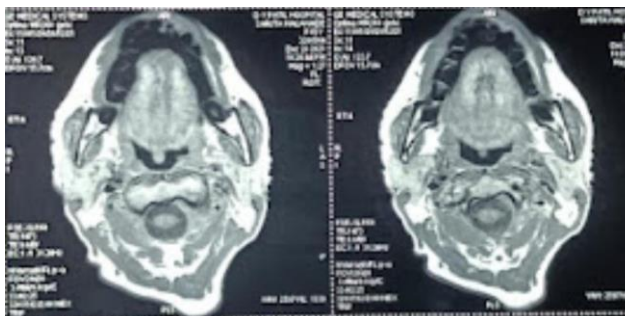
above shows axial section of Tongue MRI contrast study showing heterogenous enhancement
